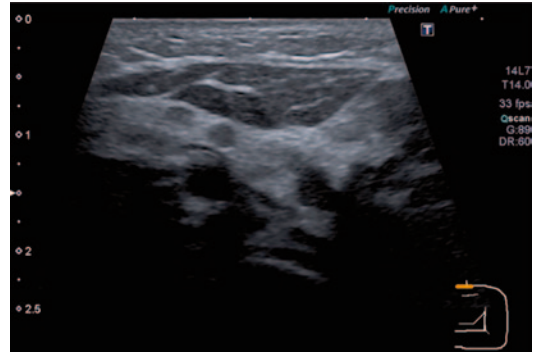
Sagittal view of the left neck in a 5-year-old boy with fever, tenderness, erythema, and swelling of the left neck. The ultrasound demonstrates an area of low echogenicity with no Doppler signal. This area extends to the surface and is within an area of adjacent enlarged lymph nodes
